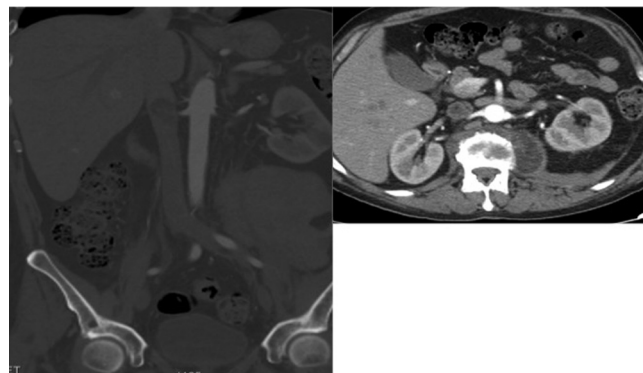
A coronal and an axial CT angiogram in which thrombi are seen in the yuxtarrenal vena cava and the left renal vein.
